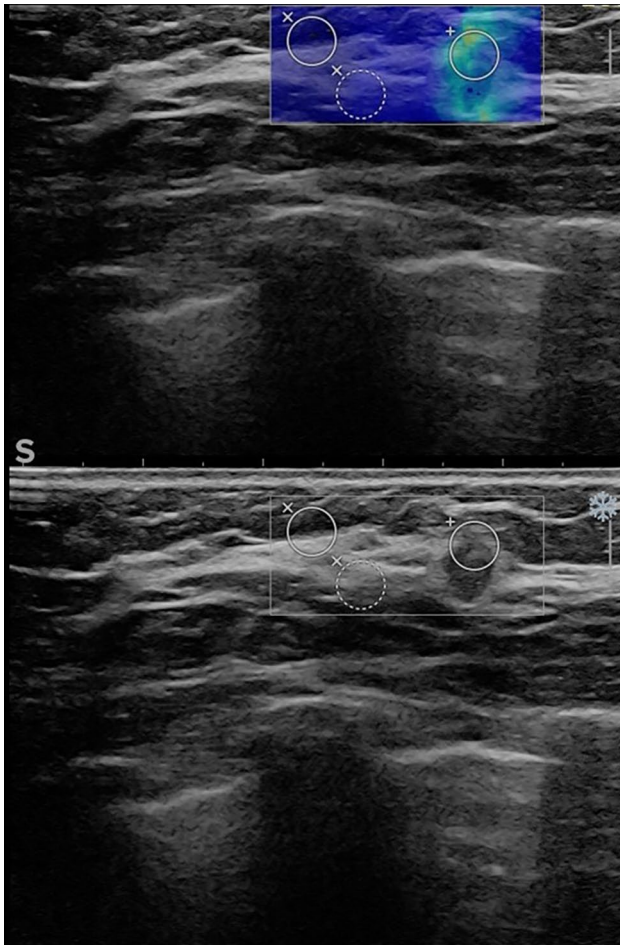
B-mode ultrasound shows a small oval hypoechoic mass, with slightly irregular margins but without a posterior acoustic shadowing. The ultra-fast SWE shows in the colorimetric map a significant increase in the stiffness of the peripheral tissue, also supported by the numerical values of the ratio between kPa suspicious tissue/kPa healthy tissue (kPa ratio 15.69). The lesion resulted to be a non-special type invasive breast cancer (B5)
